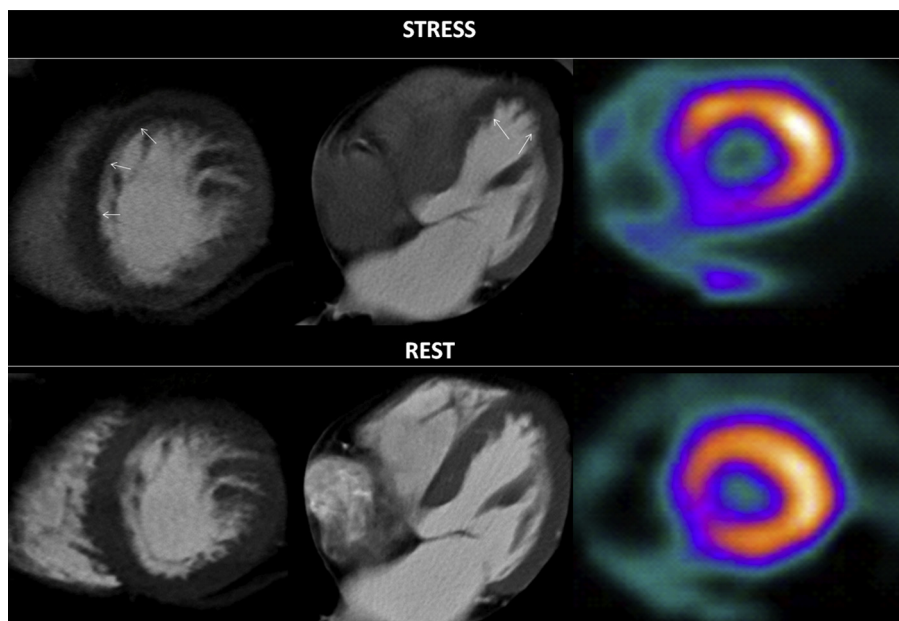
Myocardial perfusion imaging by single-energy computed tomography (SECT) in a 61-year-old male with hypercholesterolemia and previous smoking as coronary risk factors, and chest pain, referred for myocardial perfusion imaging by single-photon emission computed tomography (SPECT). *Above:* stress images of SECT in a short-axis apical view (*left panel*) and a four-chamber view (*center panel*), and SPECT imaging in a short-axis apical view (*right panel*). *Below:* corresponding rest images. SECT imaging demonstrates a perfusion defect (*arrows*) during stress in the septal and apical wall of the left ventricle, with normalization of myocardial perfusion in rest.
